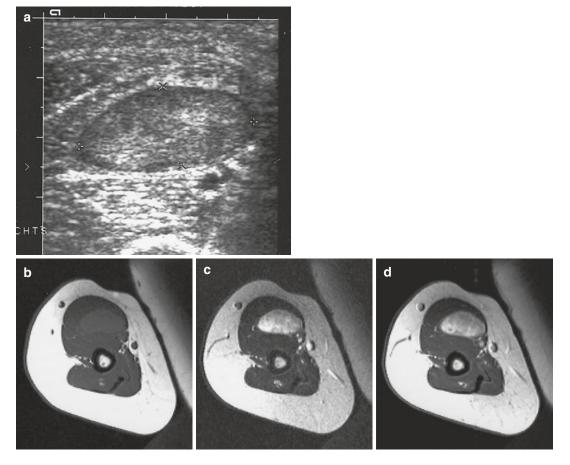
Leiomyoma of the flexor compartment of the right arm in a 56-year-old woman. (a) Ultrasound, axial plane. Ultrasound shows a well-circumscribed, oval, and slightly hypoechoic mass within the biceps muscle. (b) Axial T1-WI. The well-defined mass is hyperintense to
